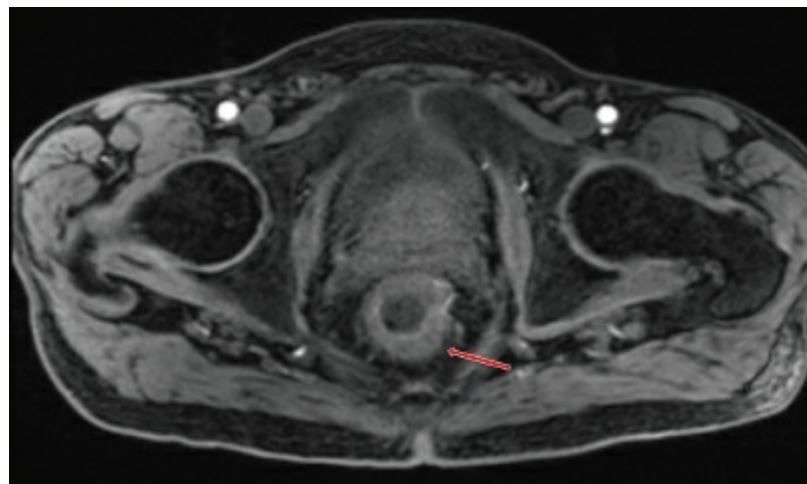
MRI demonstration of active UC with rectal wall thickening, increased vascularity, and inner layer hyperenhancement. Courtesy of Dr. William Reed.
